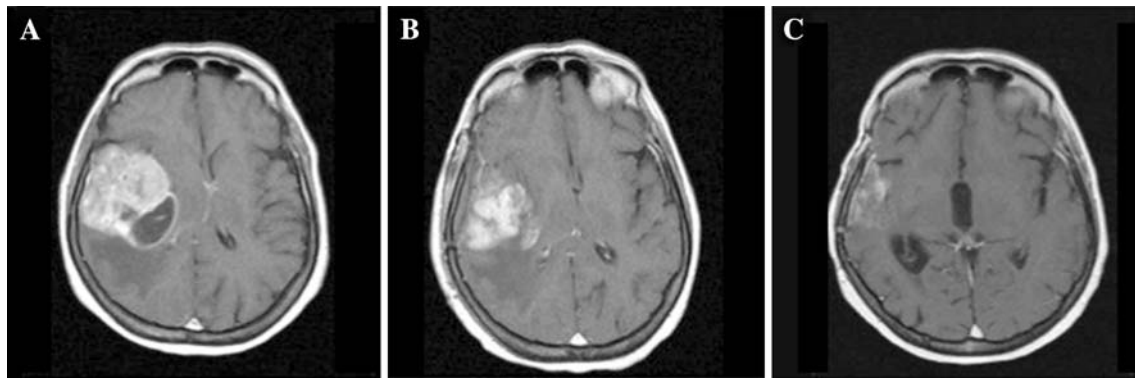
Long surviving patient after response to gemcitabine plus radiation treatment. The patient had an unmethylated MGMT promoter. a Prior to subtotal resection, MRI Spin-Echo T1 axial plane sequence after Gd-DTPA infusion shows a GBM in the fronto-temporal area.
